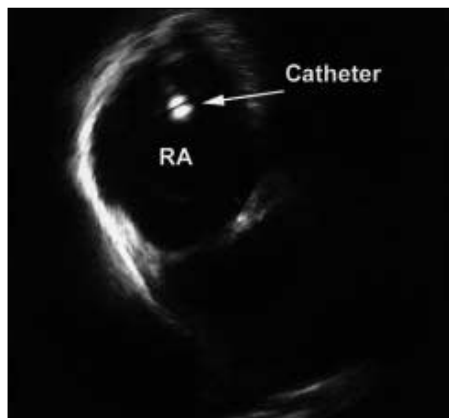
Echocardiographic view showing the Revelation T-x ablation catheter without proper wall contact
